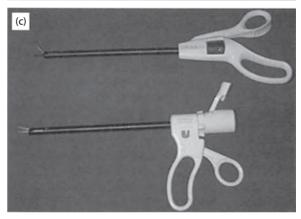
High-power ultrasonic dissection system (Ethicon). (a) Generator; (b) transducer and hand pieces for endoscopic surgery; (c) hand pieces for open surgery.
